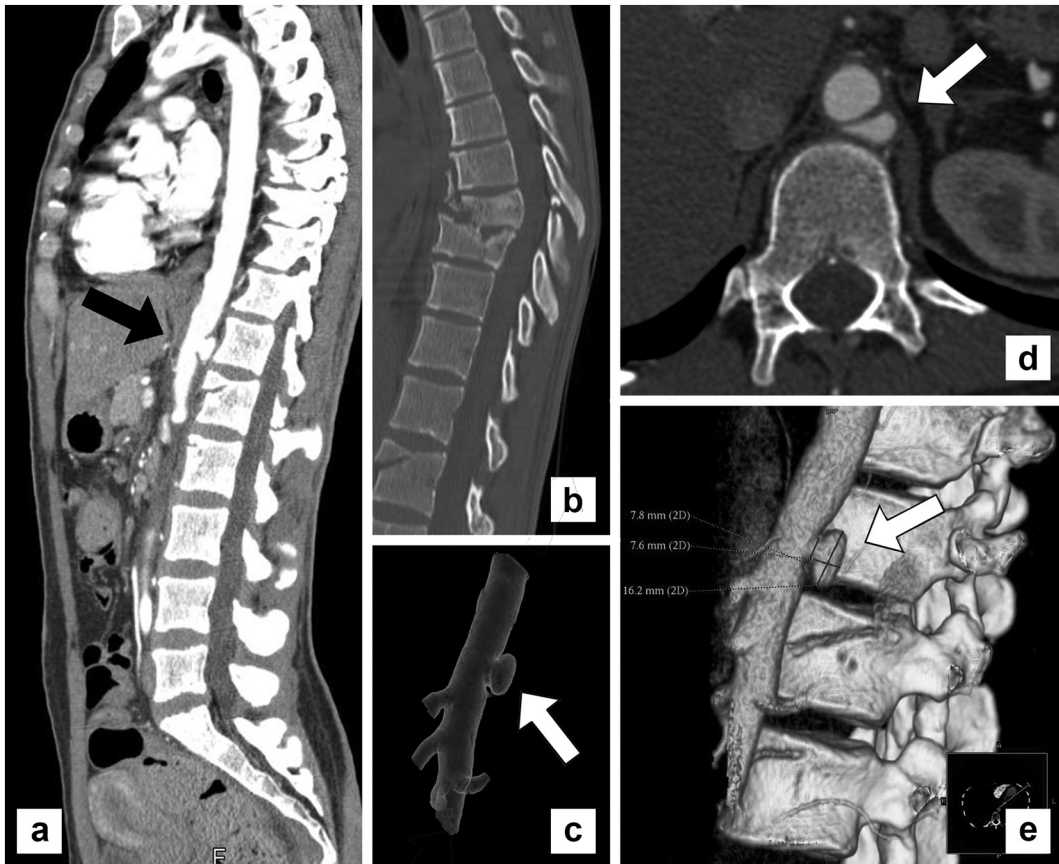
Sagittal CT image shows the aortic wall damage, and the contrast agent leaving the lumen. Black arrow indicates the location (a). CT image presents Th8-9 and L1 vertebral fractures (b). 3D CT reconstruction image of the aorta highlights the vessel injury (c). Axial CT slice shows the same pathology (d). 3D CT reconstruction image demonstrates the aortic wall disruption and its location compared to the L1 fracture (e). White arrow points at the aortic lesion (c,d,e).
